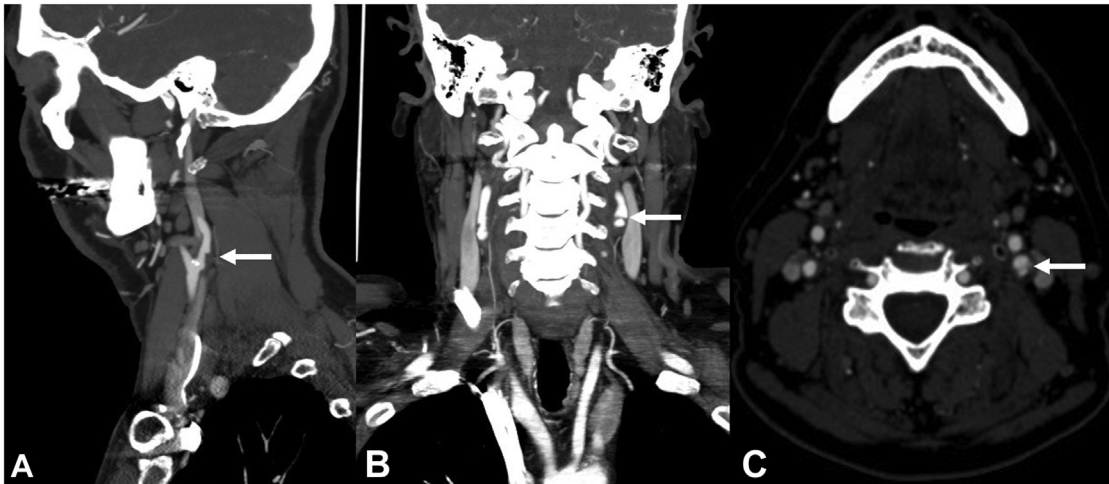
Computed tomography reconstructions of a 75-year-old male patient. White arrow shows a low-density shadow with a thin line and a focal membrane-filling defect, compatible with a carotid web. (A) Sagittal view. (B) Coronal view. (C) Axial view.
